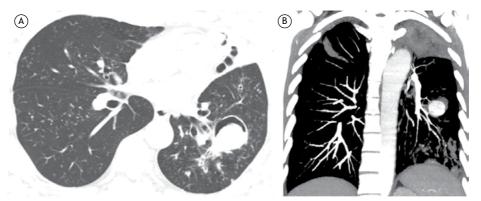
In A, axial CT scan of the chest with lung window settings, showing a nodule within a cavity, with air interposed between the nodule and the cavity wall (the air crescent sign), in the left lower lobe. Changes in patient position (not shown) resulted in no changes in the position of the nodule in the cavity. In B, coronal reconstruction showing intense contrast enhancement of the intracavitary nodule. Note the presence of small nodules in both lungs, as well as heterogeneous consolidation in the lingula, consistent with tuberculosis.
